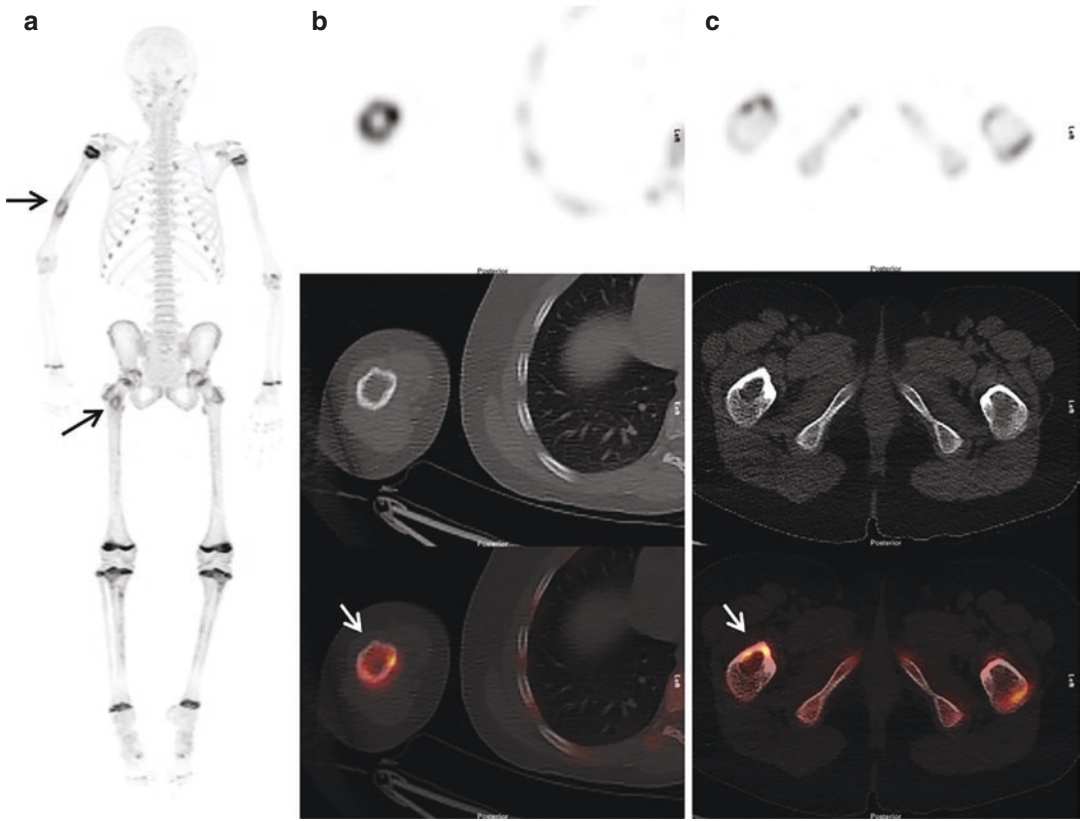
History: A 11-year-old girl complains of right hip pain for 2 months and was referred to NaF PET/CT for further evaluation. Study report: Anterior MIP (a) and selected transaxial PET, CT, and PET/CT slices at the level of the mid-thorax (b) and lower pelvis (c) show two foci of inhomogeneous increased tracer activity localized
